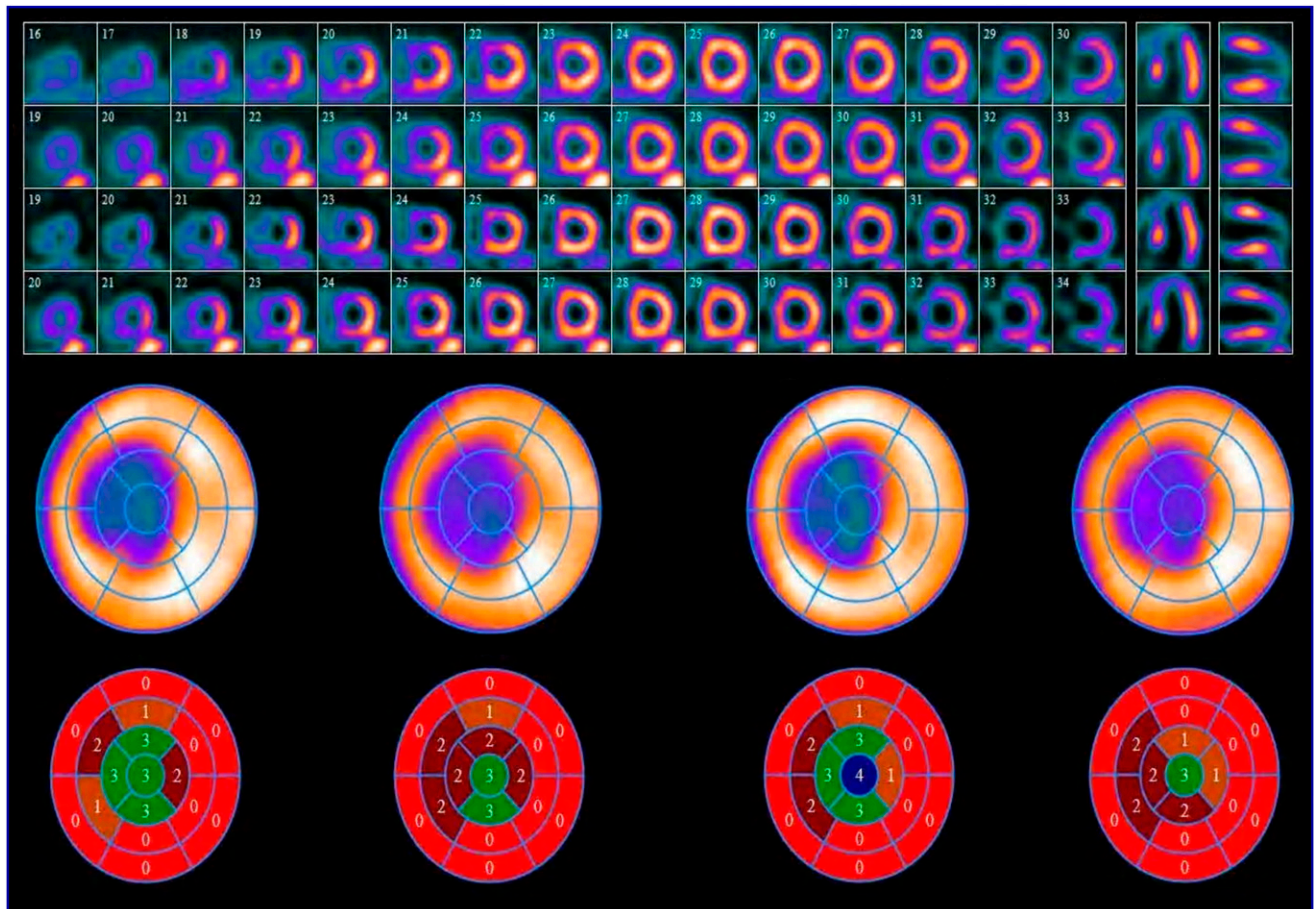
Corrected S/R low-energy high-resolution parallel-hole collimator (18 min) and IQ SPECT (4 min); 90% mid-left anterior descending artery.
